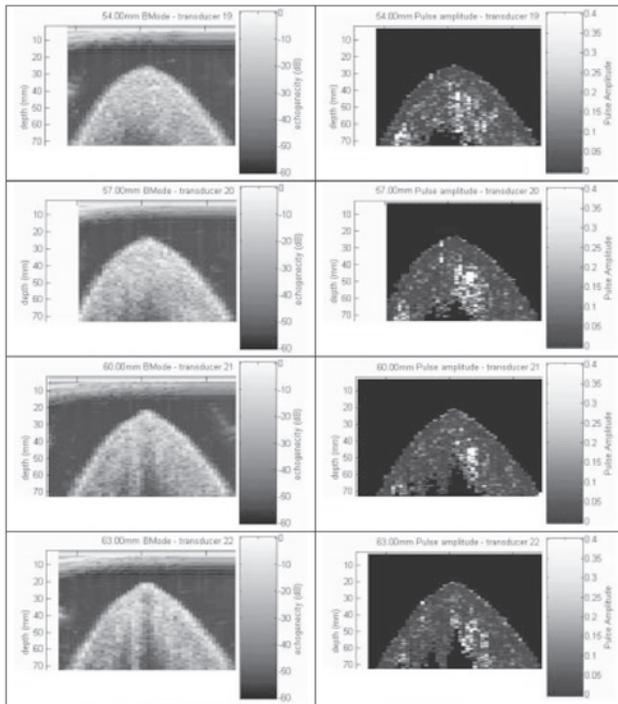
Ultrasound B-mode and Pulsatility Images of Breast Cancer
